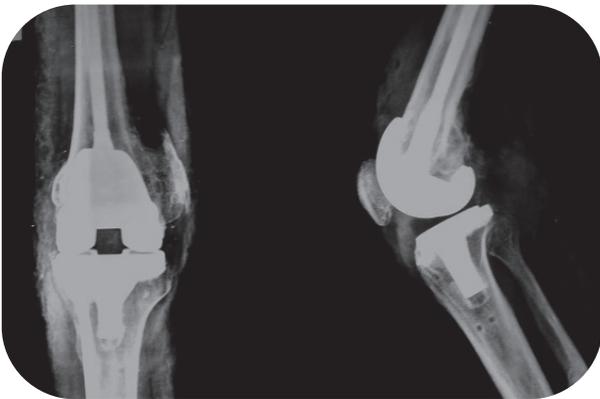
AP and Lateral radiographs of same patient showing long stem total knee arthroplasty with union at fracture site.
